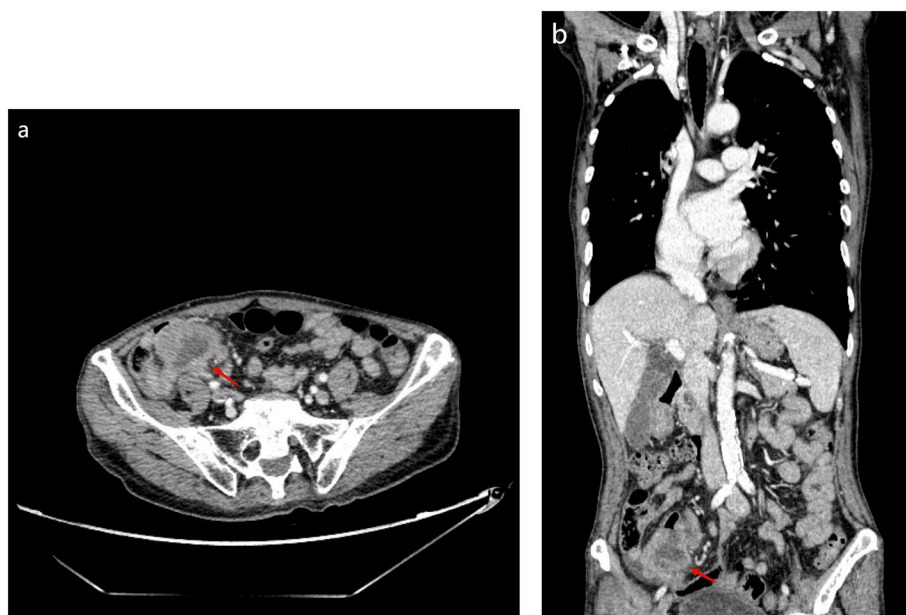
Abdominal computed tomography (CT) revealed a small intestine mass in the abdomen.
